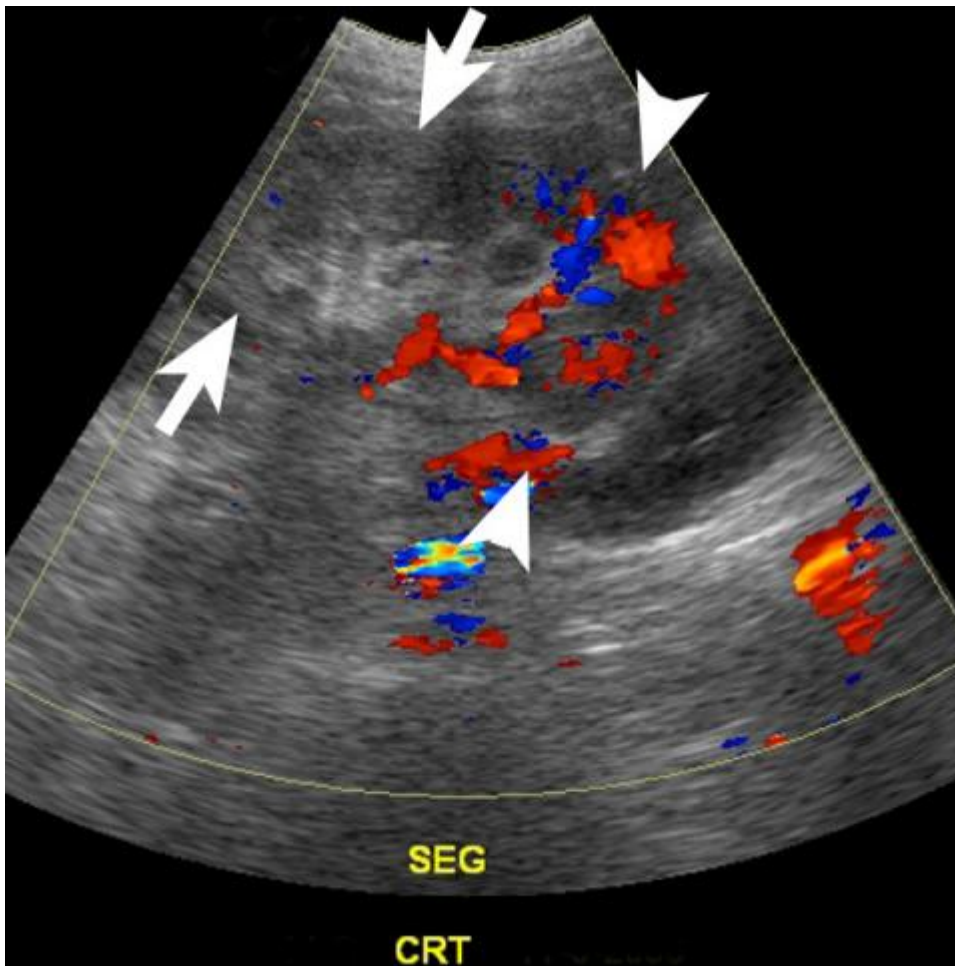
Segmental infarct. Color Doppler image shows normal flow (arrowheads) at the inferior third of the renal transplant but lack of flow in the mid and upper portions (arrows) due to segmental infarct.
